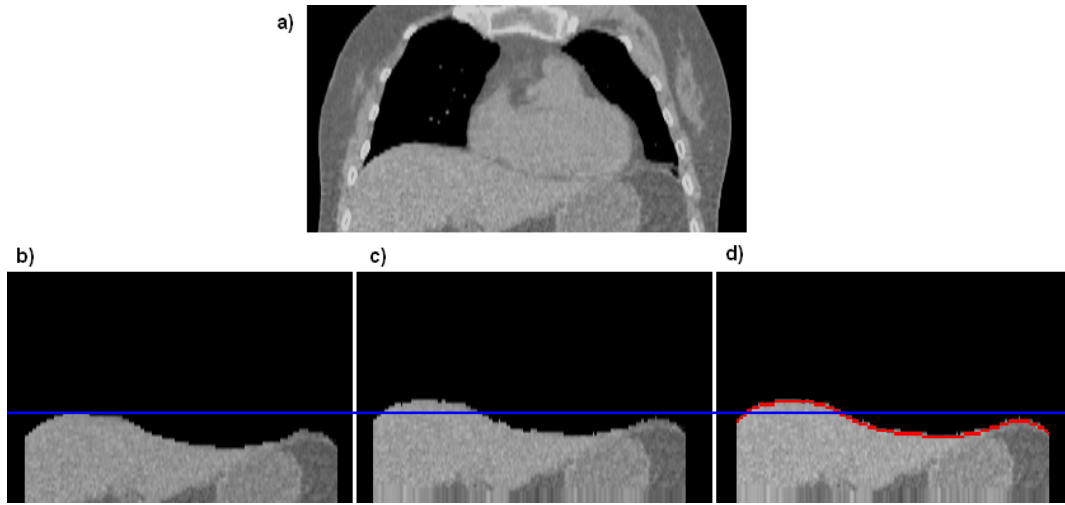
The transformation of the abdomen region from the end-inhale (reference) frame and the end-exhale frame for patient 1. a) A coronal slice of the reference CT frame, b) the abdomen region with other regions masked, c) the transformed abdomen region to match the end-exhale diaphragm position and d) the transformed region with the fitted model surface superimposed in red. The blue line is a reference point to facilitate a comparison between the diaphragm position in the original and transformed images.
